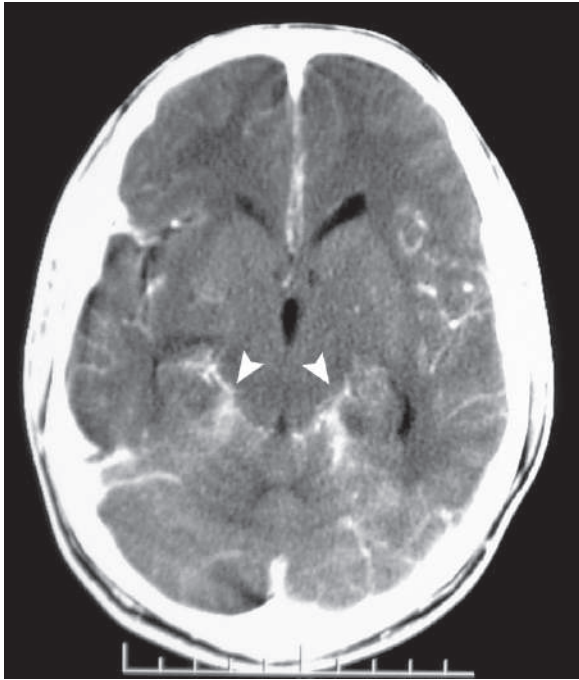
Axial postcontrast brain CT shows enhancement of the leptomeninges around the ambient cisterns (*arrowheads*)
